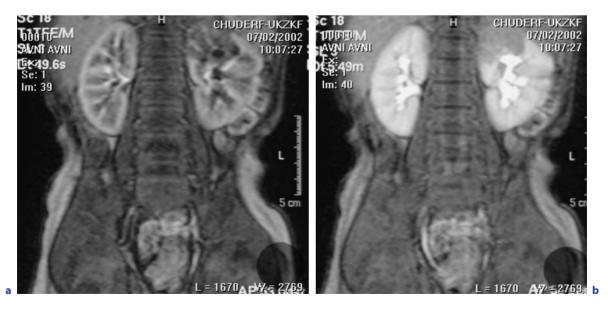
MR imaging of APN. a T1 sequence post-Gd enhancement. Early phase. Heterogeneous enhancement of the left upper pole. b T1 sequence post Gd. Late phase. No enhancement of the upper pole parenchyma is visible
